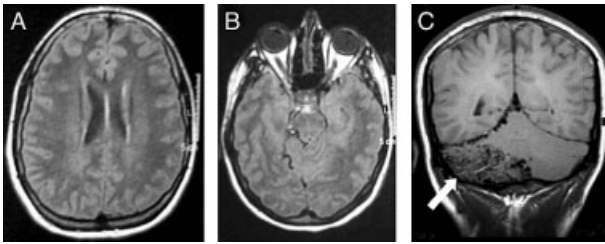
Cerebral MRI: absence of alterations in both periventricular and tempolar pole white matter (A, B); large arteriovenous malformation (arrowed) involving the right cerebellar hemisphere (C).
